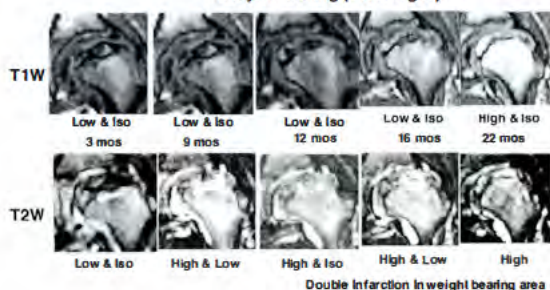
Time-sequential changes on MRI
